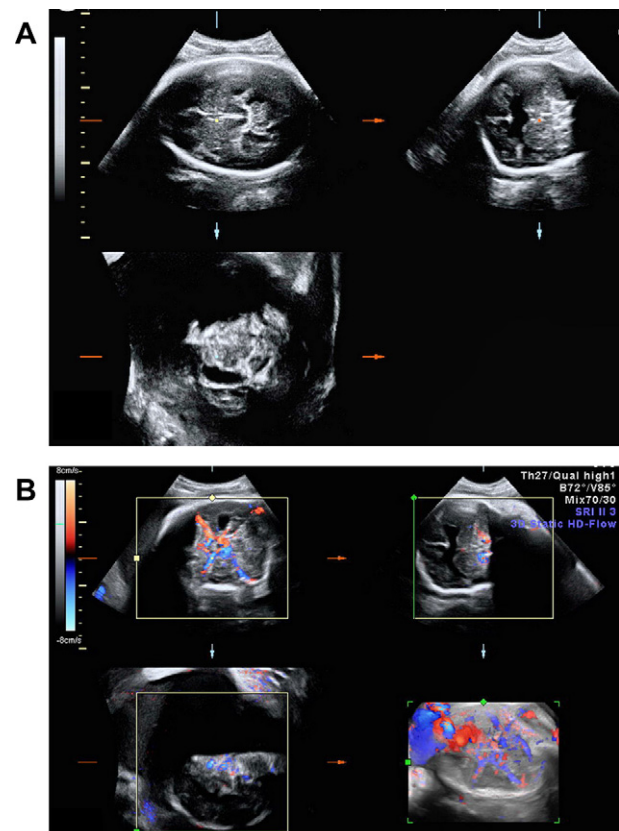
3D US revealed the lesion of fetal schizencephaly at 33 weeks. (A) Multiplanar orthogonal view by 3D US. (B) Three planes and rendering modes of fetal brain by 3D color Doppler US. 3D US = three dimensional ultrasound.
